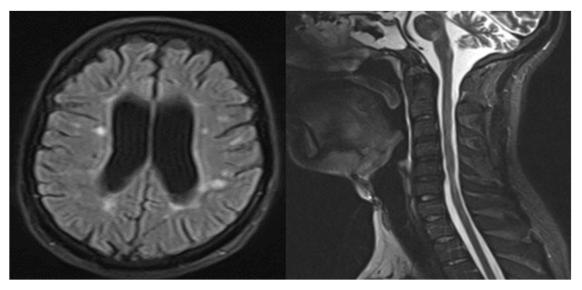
Rt: Multiple small posterolateral lower cervical, pontine, and medulla hyper-intense lesions in T2 sagittal image, Lt: multiple ovoid periventricular, subcortical, and juxtacortical hyper-intense lesions in FLAIR axial image.
